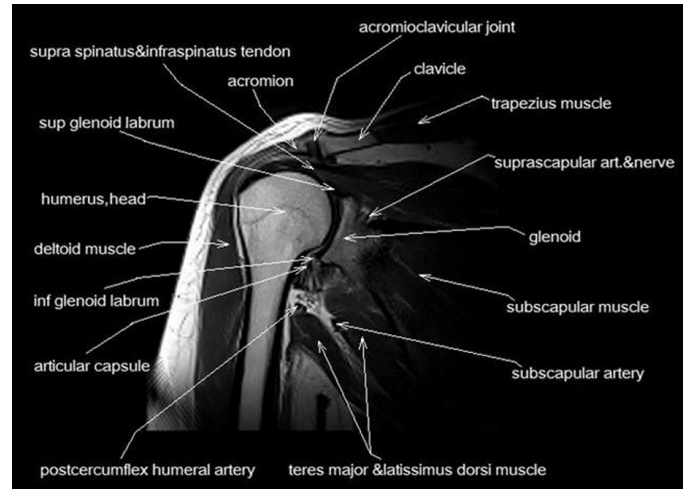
coronal shoulder MRI
